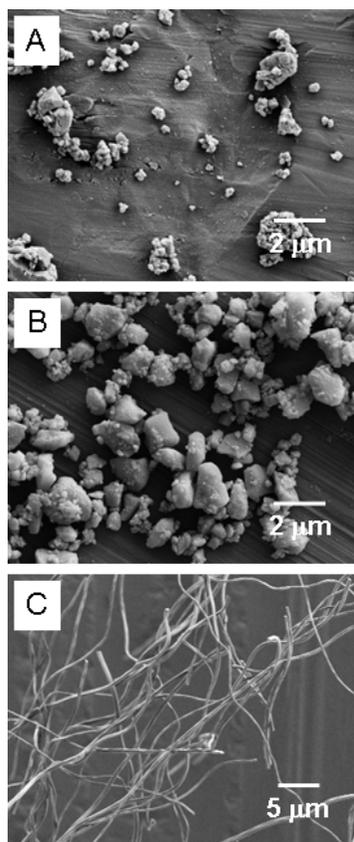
SEM images showing the representative morphologies of the Aldrich glass powder (a), the Esstech glass powder (b), and the electrospun nano-scaled glass fibers after ultrasonic vibration (c) [6].
